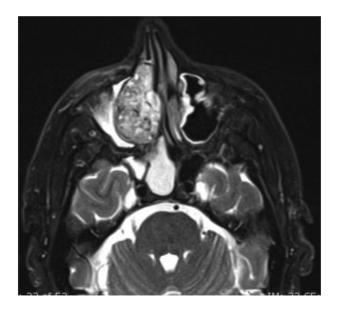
T2W Axial image of MRI paranasal sinus shows multiple flow voids within the mass suggestive of hypervascular nature of mass lesion.
